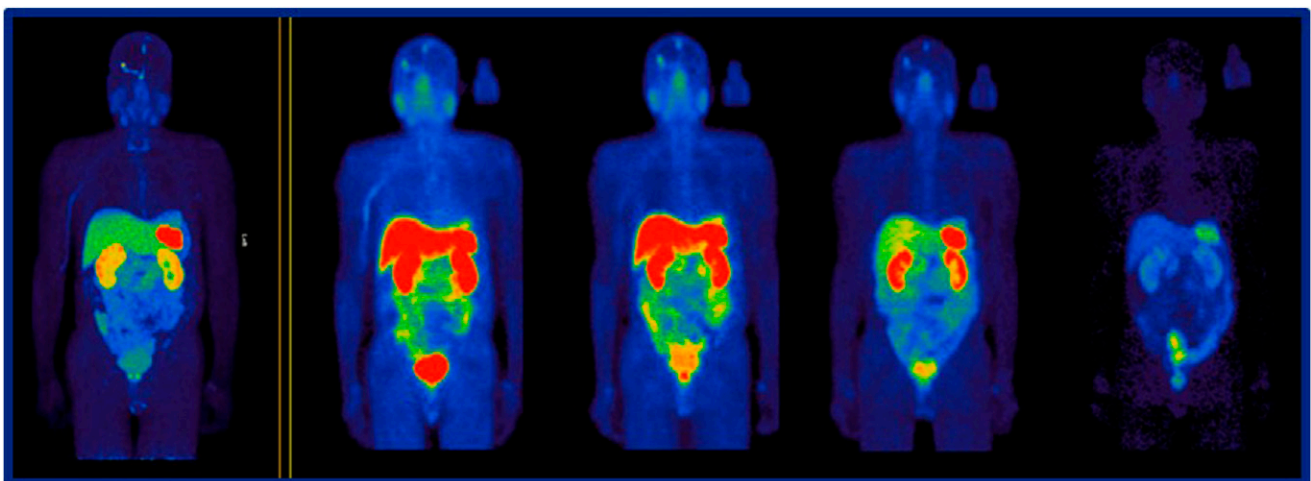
Theranostic $^{64}\text{Cu}/^{67}\text{Cu}$ with 3D pretreatment dosimetry. Subjects with somatostatin receptor-positive meningiomas received ^{64}Cu -MeCOSar-octreotate followed by 5–6 GBq of ^{67}Cu -MeCOSar-octreotate. Left to right: [^{64}Cu]Cu-SARTATE PET planning at 4 hours after injection; [^{67}Cu]Cu-SARTATE SPECT at 1, 4, 24, and 96 hours after initiation of therapy. $^{64}\text{Cu}/^{67}\text{Cu}$ -MeCOSar-octreotate appears to be a potential alternative theranostic combination for subjects with somatostatin-expressing tumors.
